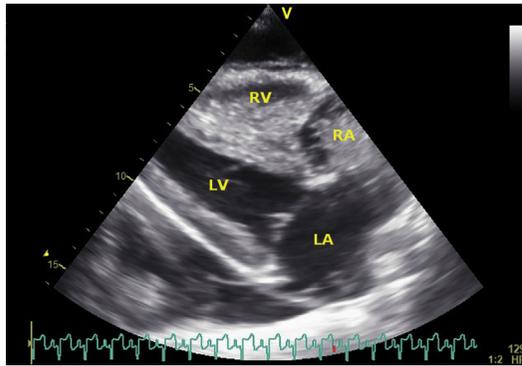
2D B-mode recording in a right parasternal long-axis, 4-chamber view. The image was captured while a saline contrast (bubble) study was being performed. The contrast is visible as hyperechoic content in the RA and the RV but not in the LA and LV. There is no evidence of an intracardiac shunt.
